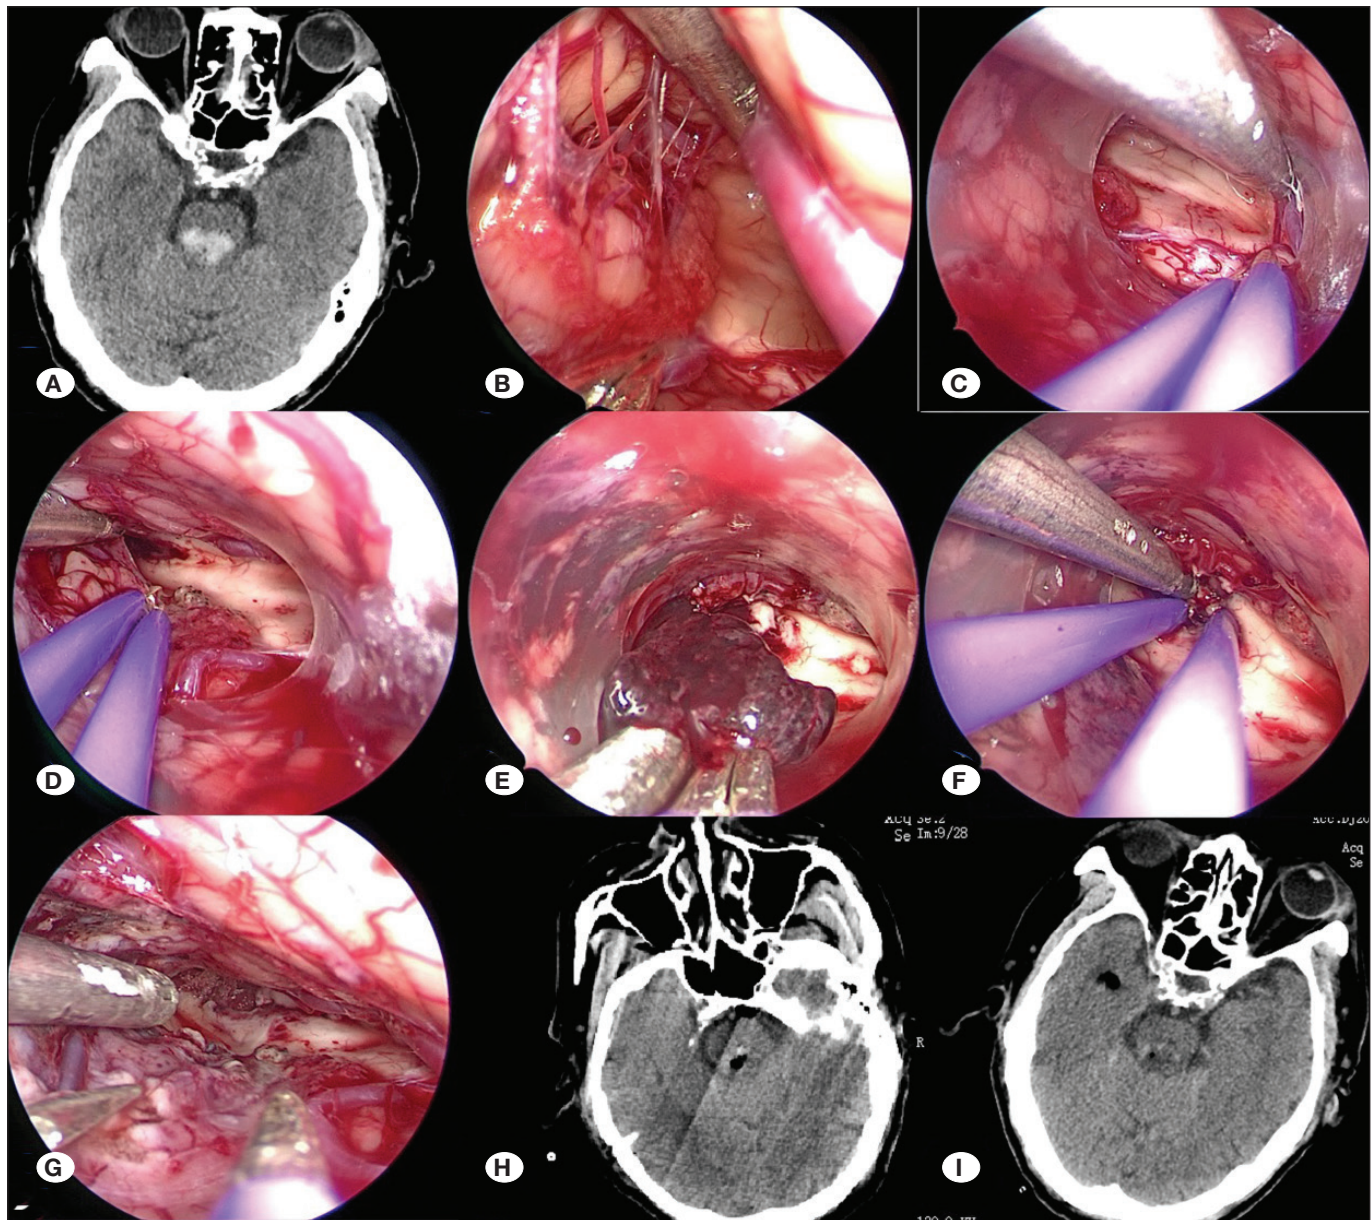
Preoperative CT examination of the head showed that the hematoma was located in the dorsal pontine region (A). The membrane medullary velum structure was opened (B). A micro-sheath (Endoport) was then implanted to explore the bottom of the fourth ventricle (C). Hematoma rupture was observed at the upper end of the fourth ventricle (D). The hematoma was removed by neuroendoscopy (E). Complete hemostasis (F). There was no obvious active bleeding (G). CT examination of the head within 24 hours revealed satisfactory brainstem hematoma clearance after surgery (H). CT examination of the head three days after surgery (I).
